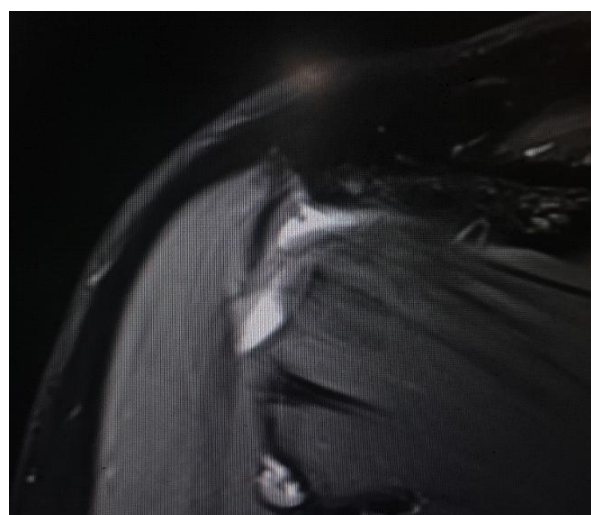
Coronal MRI Shoulder image revealing fluid in relation to Infraspinatus tendon consistent with Infraspinatus tear.
